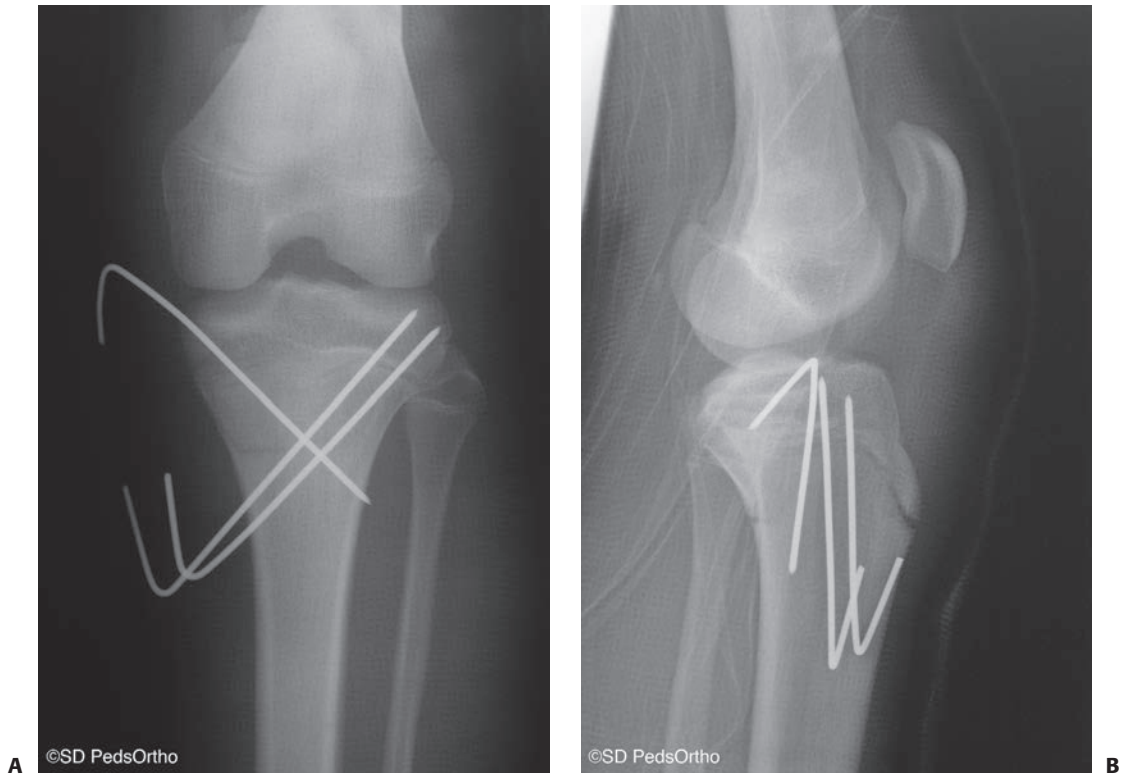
San Diego type B tibial tubercle, or Salter–Harris type 2 (with posterior metaphyseal fragment and tibial tubercle fracture). A: AP radiograph demonstrating cross-pin technique; (B) lateral radiograph demonstrating anatomic reduction with fixation.
